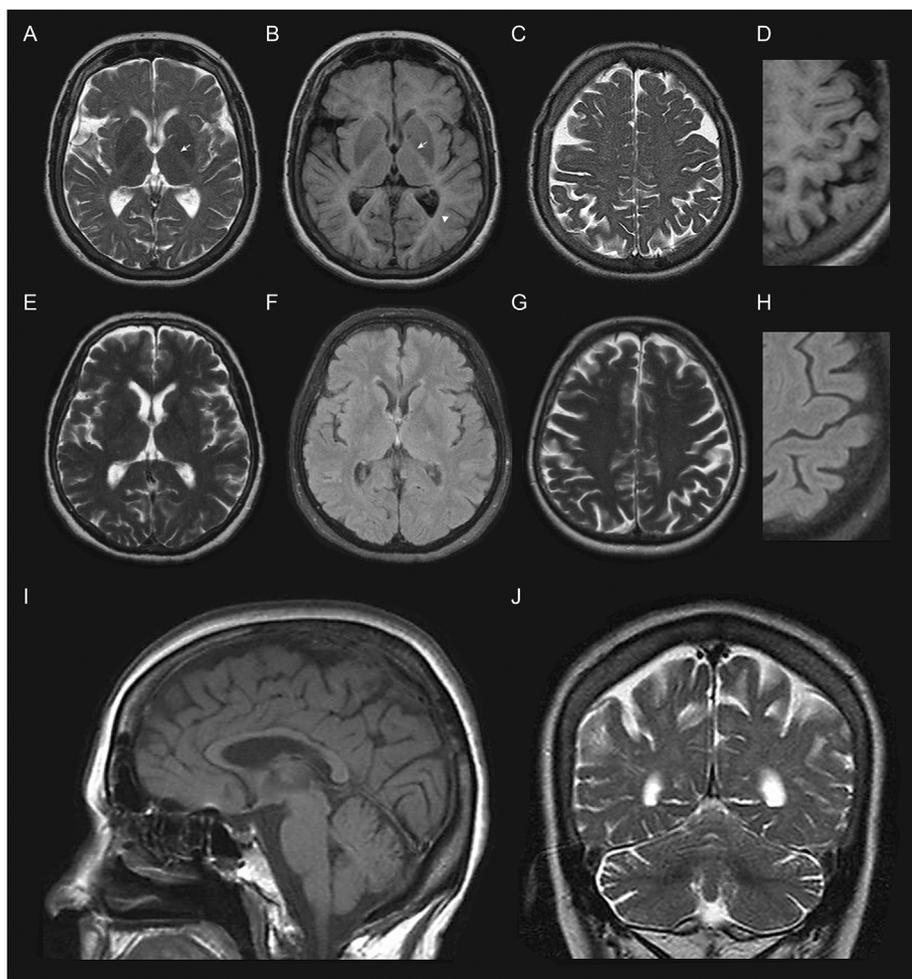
Axial T2-weighted (A, C), T2 FLAIR (B, D), sagittal T1-weighted (I), and coronal T2-weighted (J) MRI scans of patient II-4 and corresponding MRI scans of an age-matched healthy control (E–H). The images show abnormal hyperintense T2 and T2 FLAIR signal in the posterior limb of the internal capsule (arrows in A and B), in the periventricular white matter (arrowhead in B), and in the subcortical, deep and periventricular white matter (C); a “pencil lining-like” signal results from the same type of signal abnormalities at the level of the cortical circumvolutions (D). Moderate cortical atrophy and diffuse thinning of the corpus callosum are shown on the sagittal T1-weighted image (I). The coronal T2-weighted image (J) demonstrates mild atrophy of the cerebellum and subtle cerebellar peripheral white matter changes compared to the more pronounced and diffuse white matter abnormalities in the supratentorial brain (A–C).
